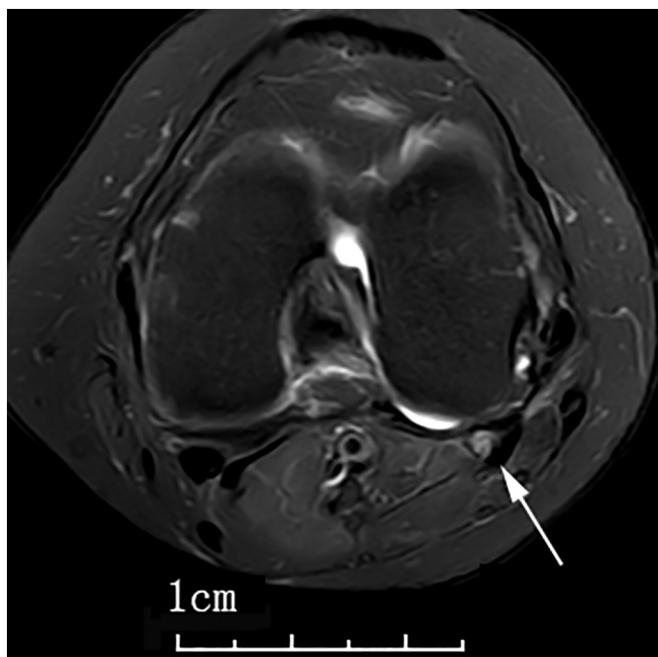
Axial T2-weighted fat-suppressed sequences revealed a low signal line within the fabella consistent with fracture (white arrow).
